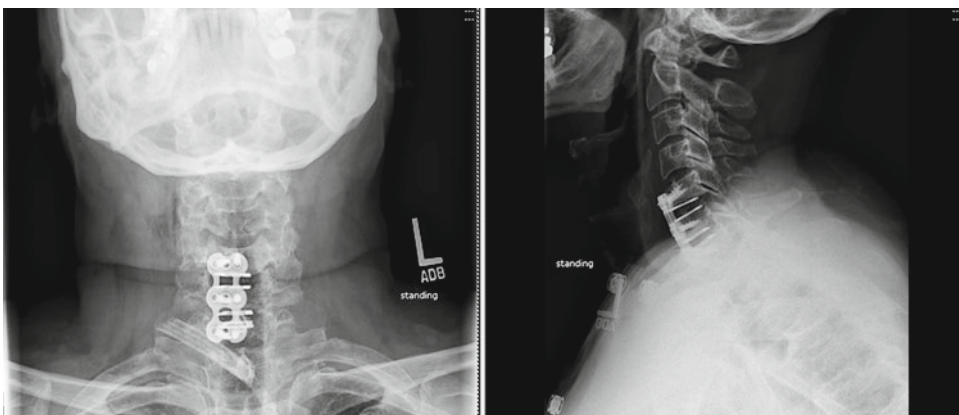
Anteroposterior and lateral radiographs demonstrating anatomic position and alignment of the cervical spine following a two-level ACDF
